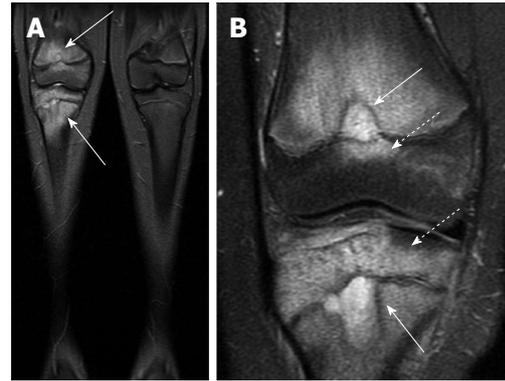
Chronic recurrent multifocal osteomyelitis. A: Coronal short-tau inversion recovery image from whole body magnetic resonance imaging (lower extremity station) shows areas of bone marrow edema in the distal femur and proximal tibia; B: Coronal T2-weighted fat suppressed image with smaller field of view again demonstrates the bone marrow edema as well as two areas of very hyperintense T2 signal in the femur and tibia which may represent intraosseous abscesses (solid arrows), though these are not typically found in chronic multifocal recurrent osteomyelitis. Involvement of the epiphysis is apparent at both sites (dashed arrows).
